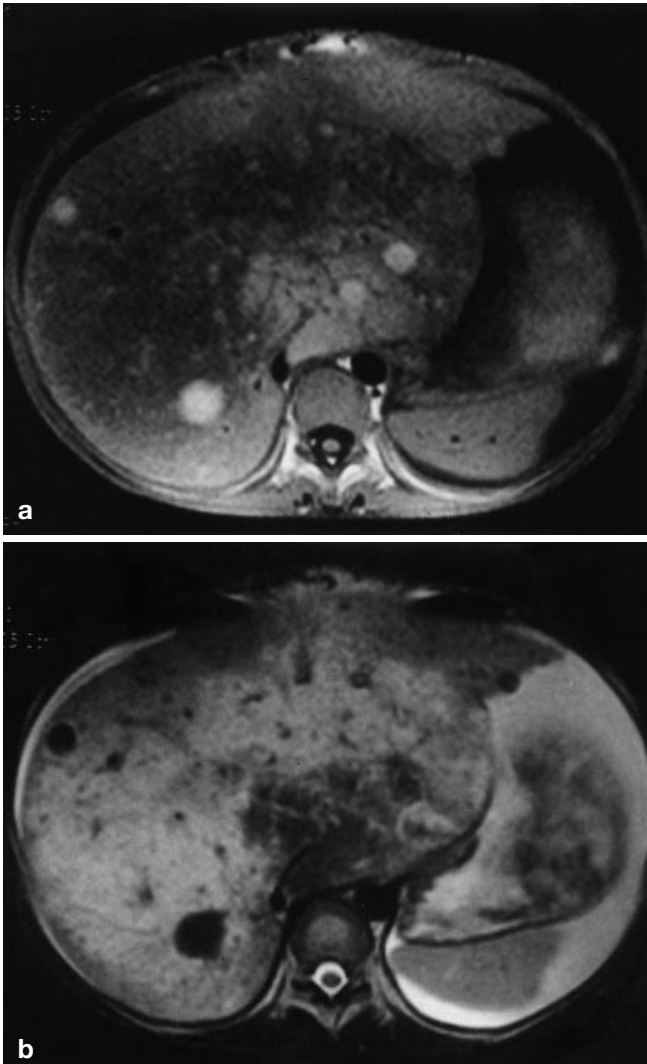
Macroregenerative nodules in Budd-Chiari syndrome. a T1-weighted image shows multiple, small, hyperintense nodular lesions within the diseased liver. b On the T2-weighted image, the lesions appear markedly hypointense
